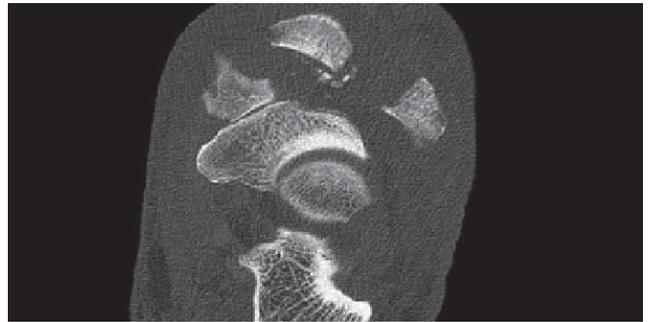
CT-scan of the left foot.
